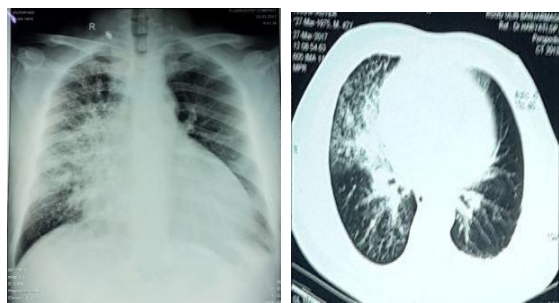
(a) Chest X-ray showing cardiomegaly and right lung consolidation; (b) Thoracic CT scan showing a primary malignant right lung mass.
